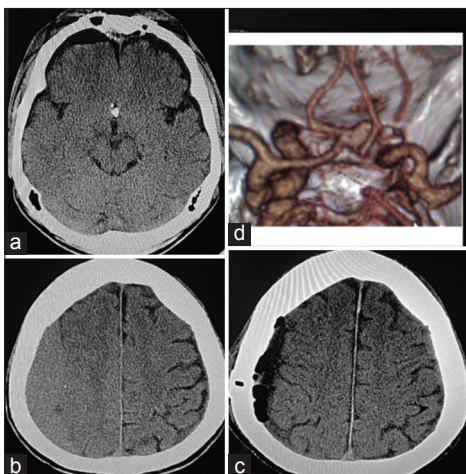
(a) Postoperative computed tomography of anterior communicating aneurysm clipping with dead space with pneumocephalus right frontal lobe, (b) follow up computed tomography head at 3 months, large chronic subdural hematoma/hygroma with no mass effect, (c) postoperative computed tomography head showing complete evacuation of chronic subdural hematoma/hygroma, (d) 3D computed tomography angiography showing anterior communicating aneurysm
